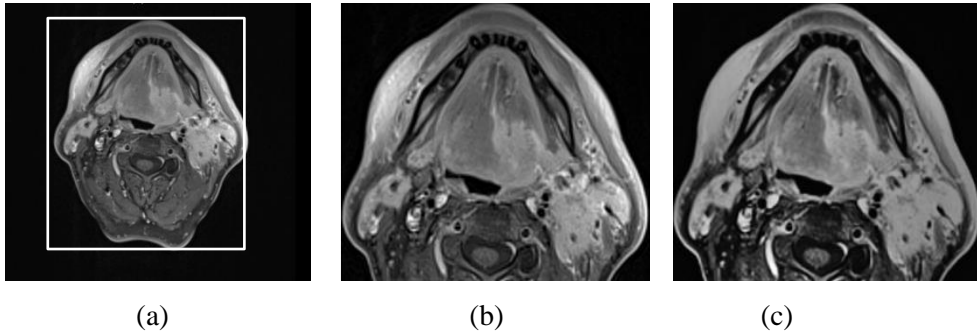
(a) Original MRI slice (white box: active area) (b) original ROI (c) pre-processed ROI which is further employed for segmentation of a tumour (ROI: region of interest).
